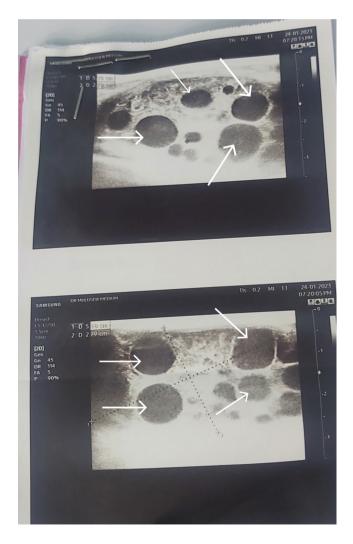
A sonographic image showing multiple daughter cysts (see white arrows). 55×88 mm (300×300 DPI).
